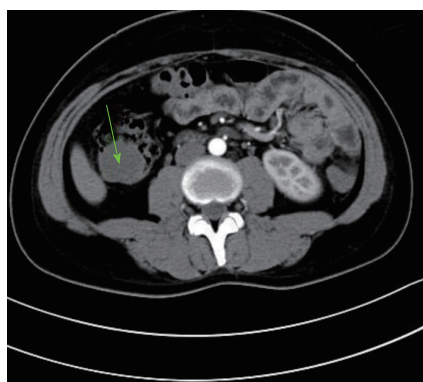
Photograph of computed tomography-scan abdomen shows hypoattenuating tumor of the ascending colon (green arrow).
